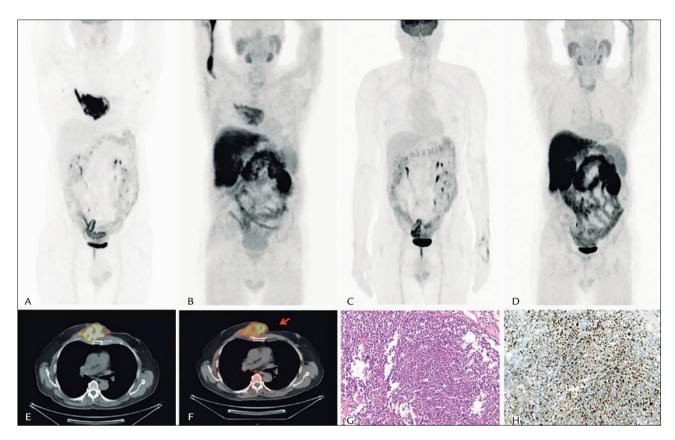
A 61-year-old man diagnosed with sternal cutaneous large B-cell non-Hodgkin lymphoma (NHL) (Panel G) underwent PET/CT scans pre- and post-therapy for tumor staging and assessment of response to treatment, respectively, using ¹⁸F-FDG and ¹⁸F-choline. The ¹⁸F-FDG uptake (A and E) showed intense metabolic activity in areas of the tumor with high proliferative pattern (Panel H – strong and diffuse positivity for Ki-67). However, the uptake of ¹⁸F-choline (B and F) was more intense in areas of lower glucose consumption of the tumor (arrow).
